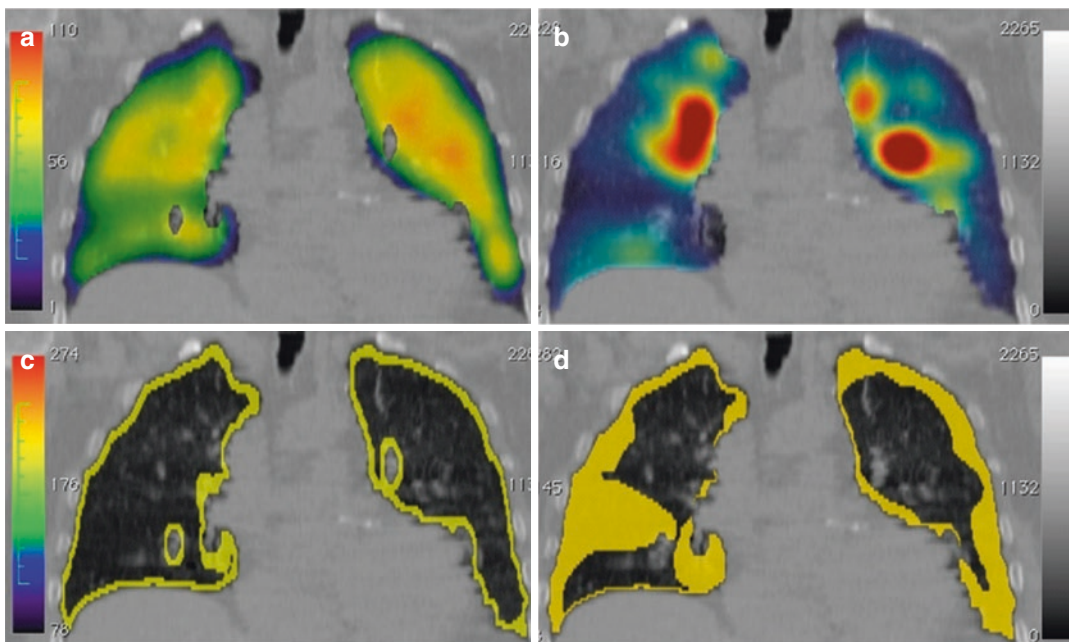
(a) Ventilation SPECT/CT fusion image (coronal view) of an asthmatic subject who had severe airway hyperresponsiveness. (b) Ventilation SPECT/CT fusion after methacholine challenge when FEV1 had decreased by around 25%. (c) and (d) are processed images showing
